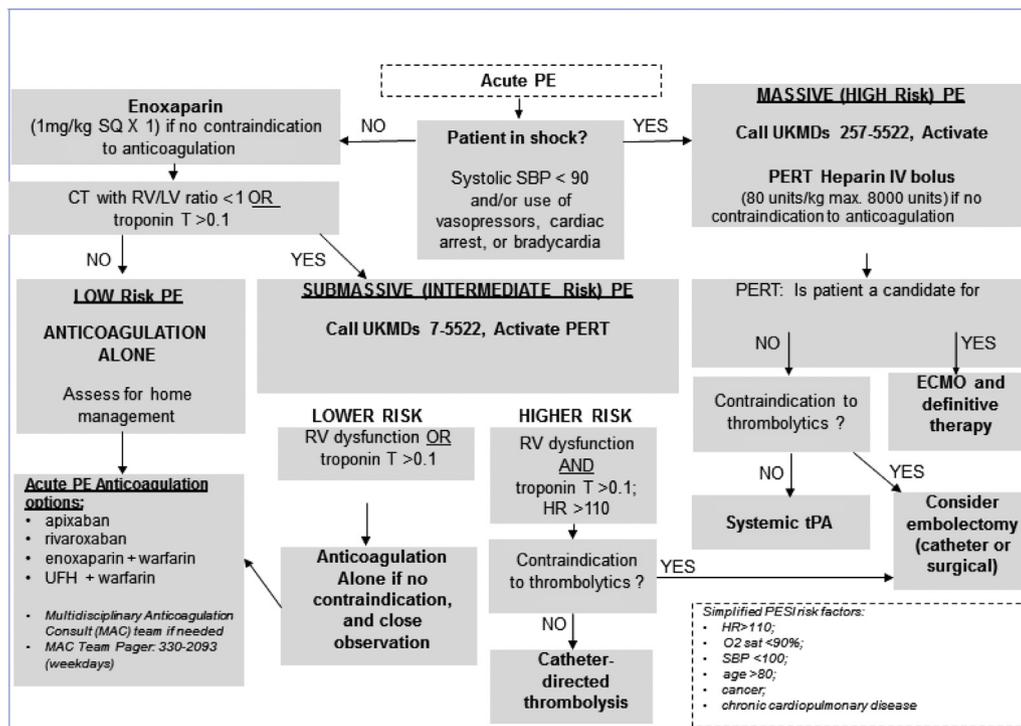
University of Kentucky pulmonary embolism (PE) risk stratification and treatment algorithm. CT, Computed tomography; ECMO, extracorporeal membrane oxygenation; HR, heart rate; IV, intravenous; PERT, pulmonary embolism response team; PESI, Pulmonary Embolism Severity Index; RV, right ventricle; RV/LV, right ventricular/ left ventricular ratio; SBP, systolic blood pressure; SQ, subcutaneous; tPA, tissue plasminogen activator; UFH, unfractionated heparin.
